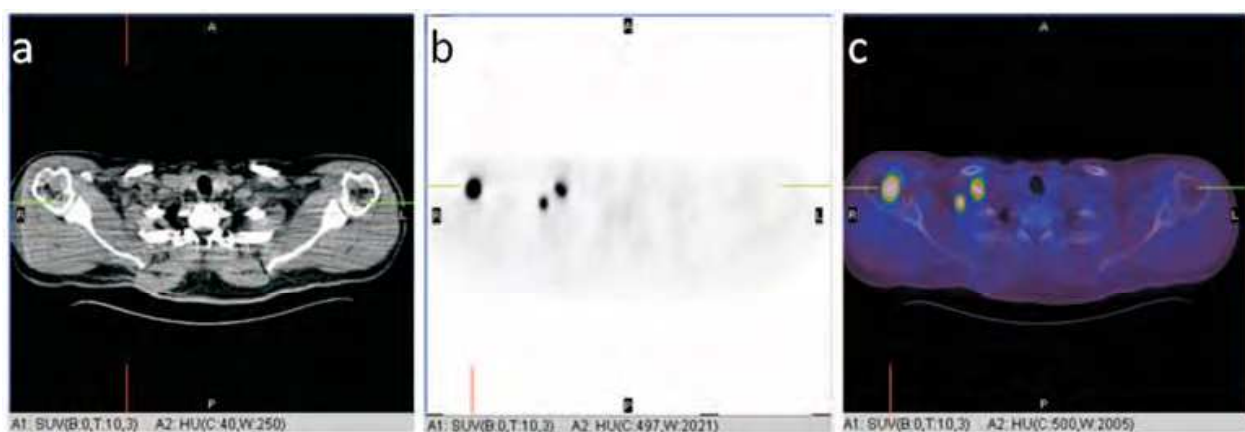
$^{18}\text{F}$ -fluorodeoxyglucose PET/CT for restaging of a 56-year-old patient with a superficial spreading melanoma of 4.3 mm depth at the right shoulder after resection of a lymph-node metastasis at the right neck. (a) CT, (b) PET and (c) fused PET/CT images showed two lymph-node metastasis infraclavicular, and PET showed an additional metastasis that was found to be localized in the right humerus head after image fusion. Image adopted from Reinhardt et al., 2006.
